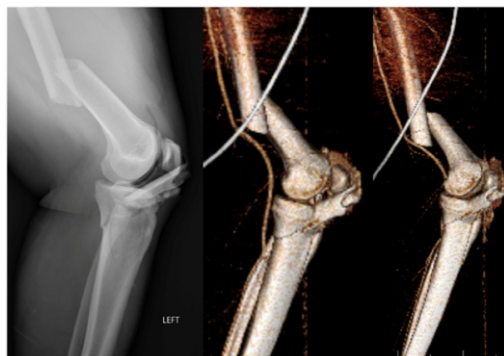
Patient A's lateral knee X-ray and three-dimensional computed tomography reconstructions, demonstrating the impaled cortical fragment in the proximal tibia. A distal-third femur fracture and tibial plateau fracture are also visualized on imaging.
